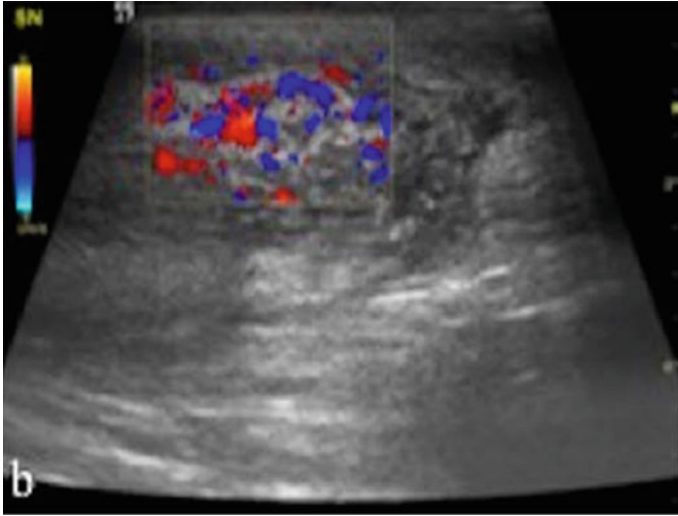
Acute epididymitis on doppler US, showing a heterogeneous echotexture with increased blood flow⁶
